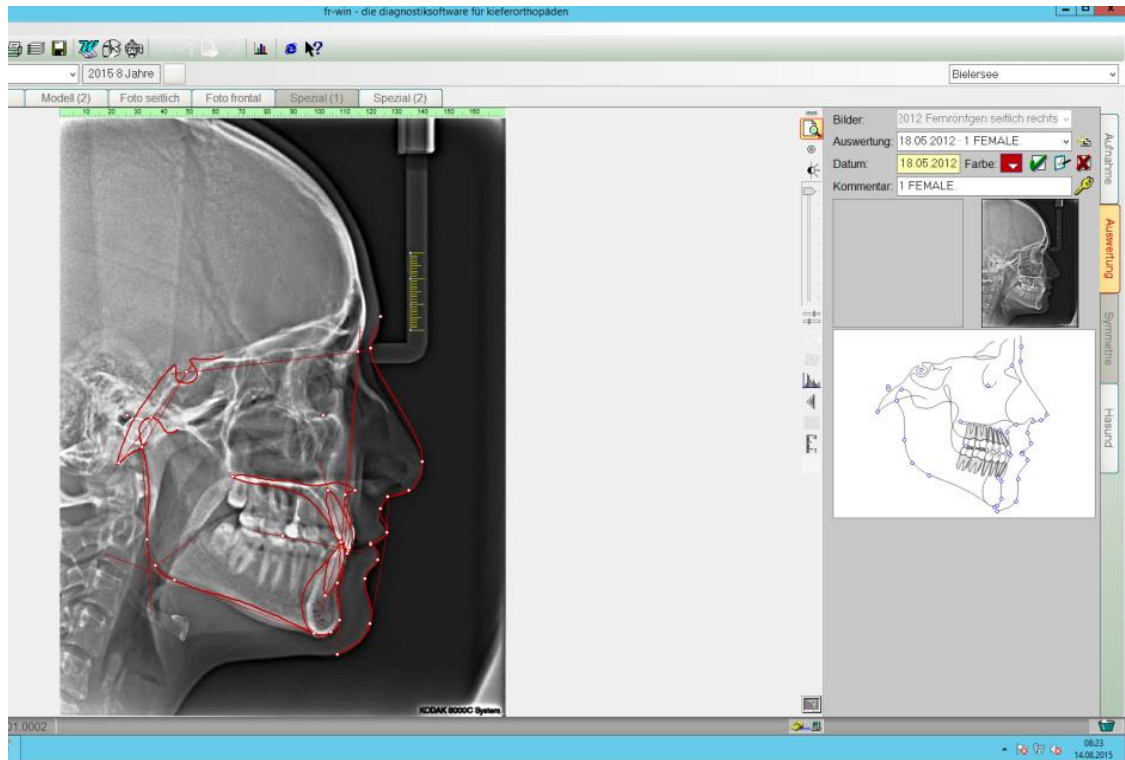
X-ray cephalometric analysis by the FRwin ceph professional program
